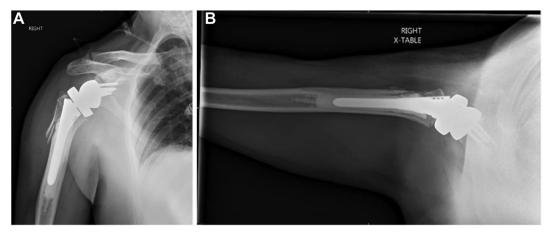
Postoperative x-rays following reverse shoulder arthroplasty procedure. (A) An AP view of the right shoulder. (B) An axial view of the right shoulder. AP, anterior posterior.
